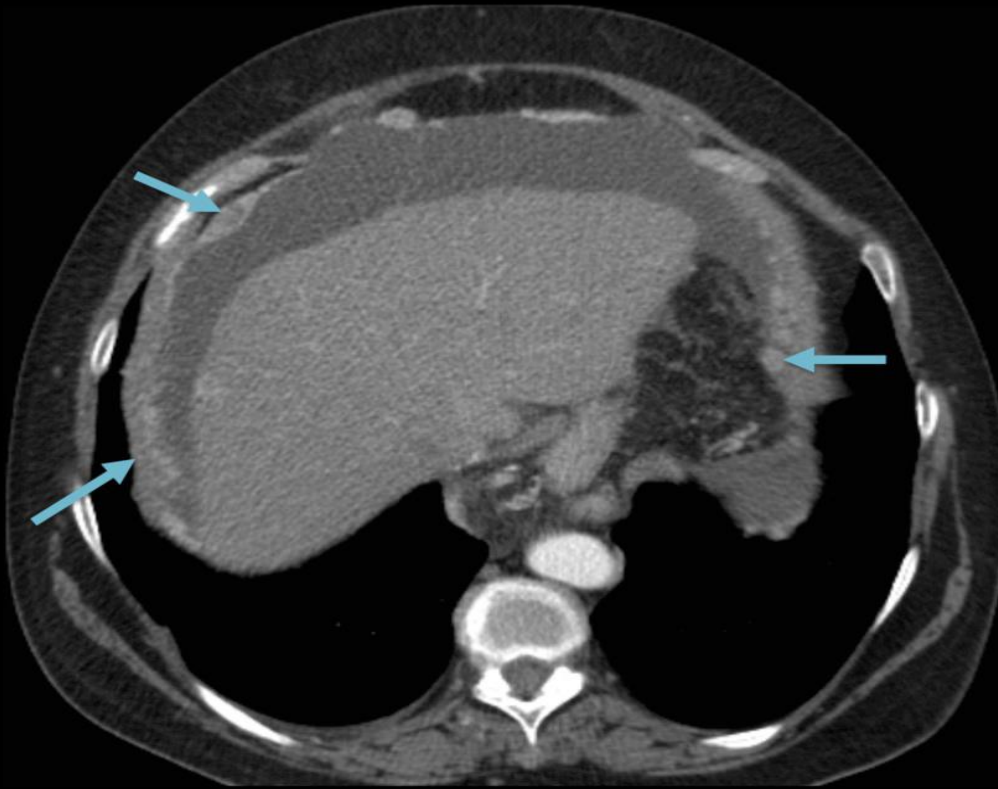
Thickening and nodularity of the peritoneum. Axial CT image from a patient with widespread metastases from gallbladder carcinoma showing diffuse thickening, enhancing and nodularity of the peritoneum (arrows). This is a typical finding in peritoneal carcinomatosis.
